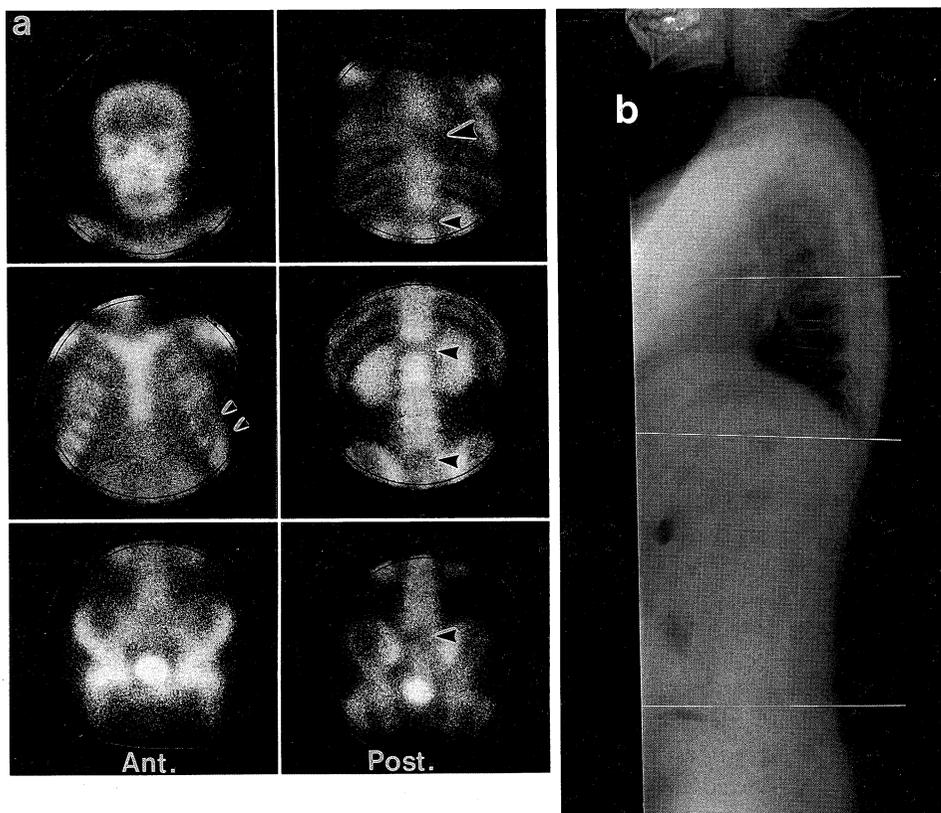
a : Bone scintigraphy: Multiple cold defects were noted in the ribs, thoracic and lumbar spines.
